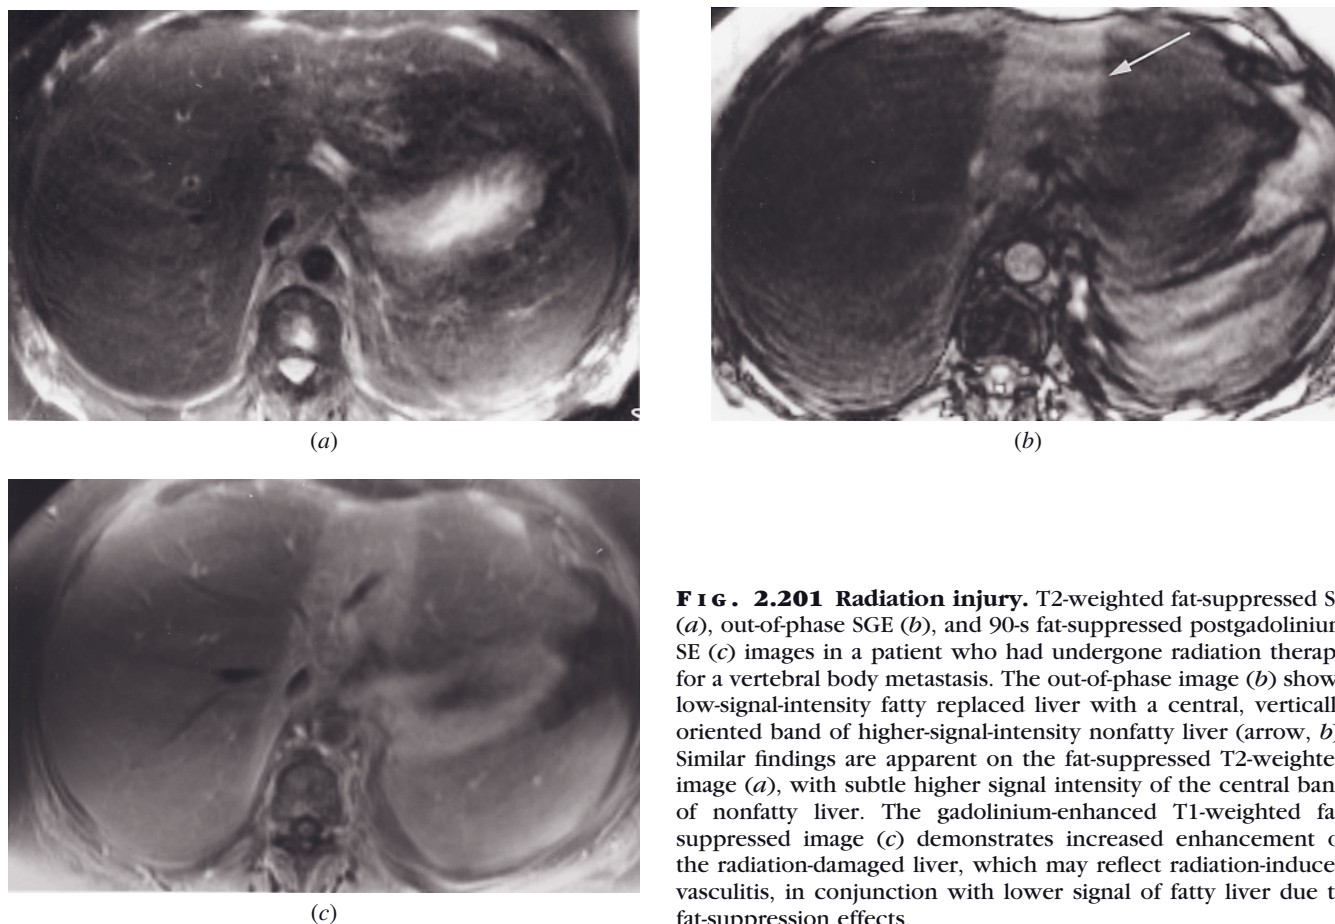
Radiation injury. T2-weighted fat-suppressed SE (a), out-of-phase SGE (b), and 90-s fat-suppressed postgadolinium SE (c) images in a patient who had undergone radiation therapy for a vertebral body metastasis. The out-of-phase image (b) shows low-signal-intensity fatty replaced liver with a central, vertically oriented band of higher-signal-intensity nonfatty liver (arrow, b). Similar findings are apparent on the fat-suppressed T2-weighted image (a), with subtle higher signal intensity of the central band of nonfatty liver. The gadolinium-enhanced T1-weighted fat-suppressed image (c) demonstrates increased enhancement of the radiation-damaged liver, which may reflect radiation-induced vasculitis, in conjunction with lower signal of fatty liver due to fat-suppression effects.
